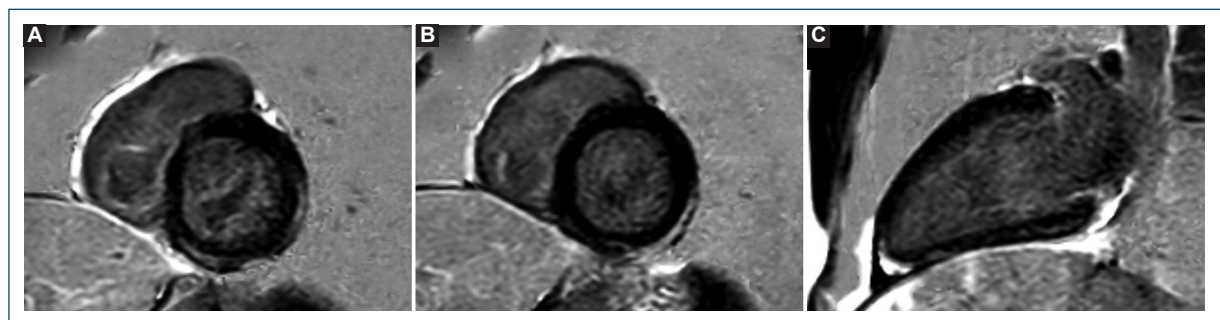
Late gadolinium enhancement with cardiac magnetic resonance imaging. phase-sensitive inversion recovery sequences. Note the subepicardial and intramyocardial pattern. A: basal short axis. B: mid short axis. C: 2-chamber long axis.
